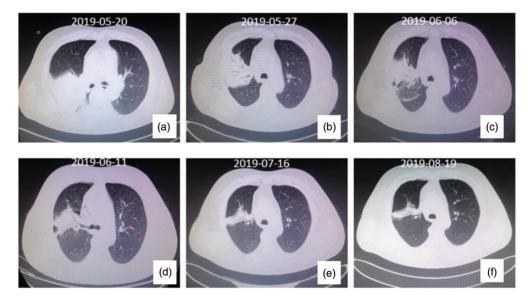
a–f: Dynamic changes in the patient's pulmonary computed tomography (CT) images from May to August 2019. The images show that the right lung consolidation decreased significantly
